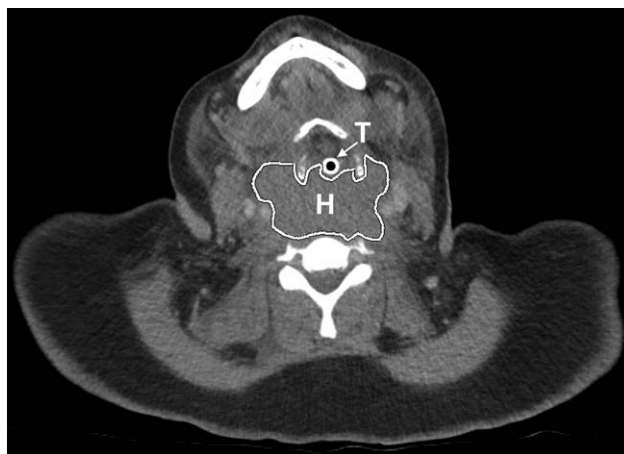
CT scan (transversal axis) on the day of admission revealing expansion of the hematoma in the pharyngeal space. CT indicates computed tomography; H, hematoma; T, tube.
